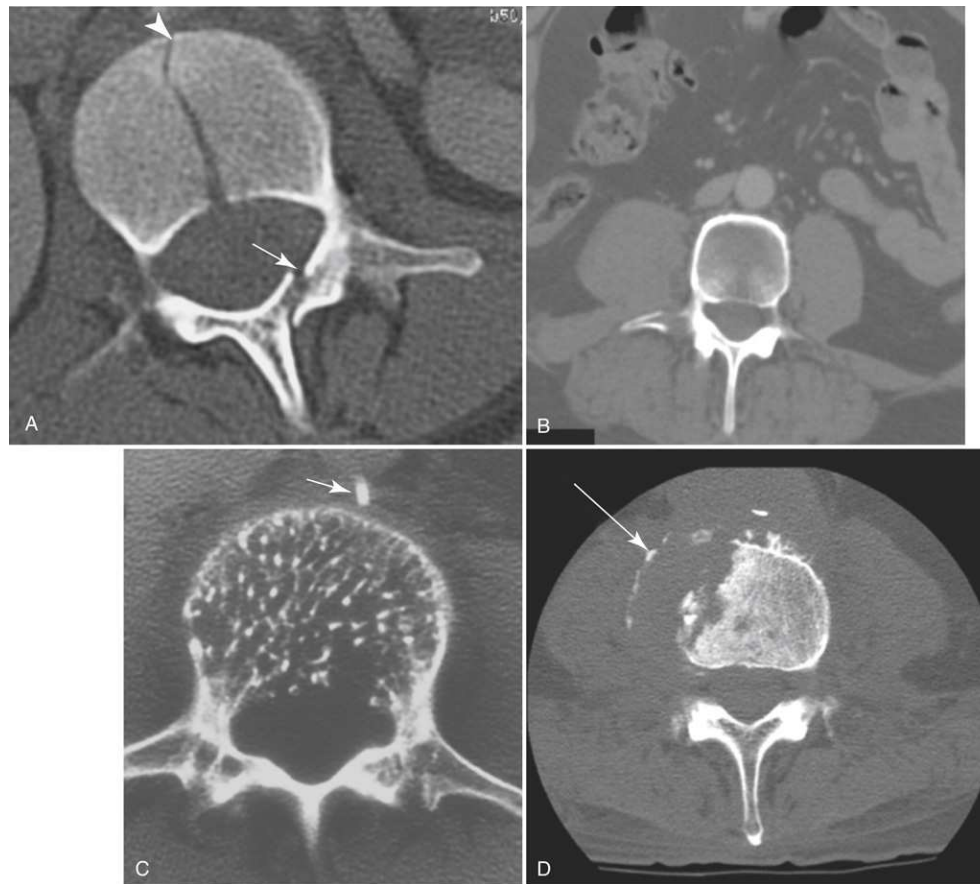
Value of using CT for further evaluation of lumbar spine. Axial images. (A) Burst fracture of L2. Fracture of vertebral body (*arrowhead*) and fracture of left lamina (*arrow*). (B) Fracture of transverse process of L4. (C) Hemangioma of L3 with no involvement of pedicles or laminae. *Arrow* points to catheter in common third artery for CT angiography. (D) Osteomyelitis seen in L3. *Arrow* points to tuberculous abscess with paravertebral calcification in wall.
